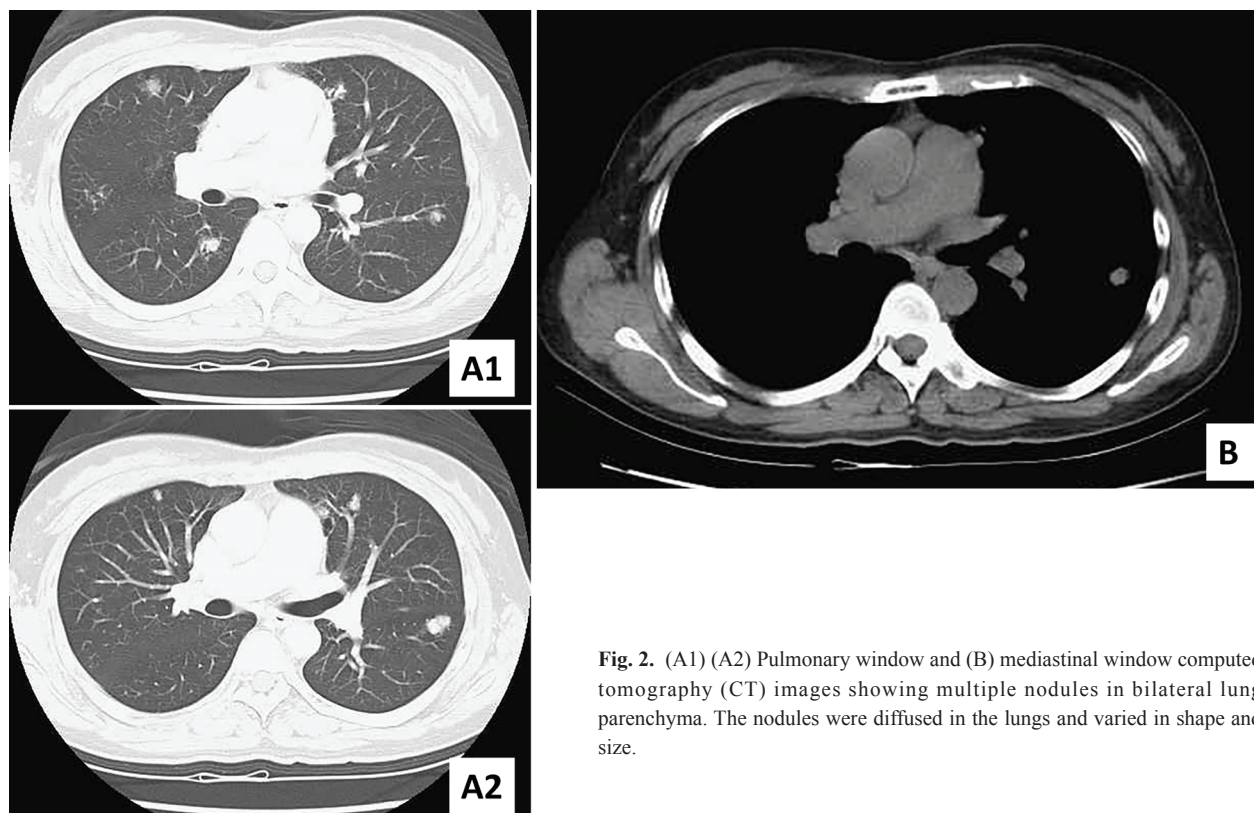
(A1) (A2) Pulmonary window and (B) mediastinal window computed tomography (CT) images showing multiple nodules in bilateral lung parenchyma. The nodules were diffused in the lungs and varied in shape and size.
